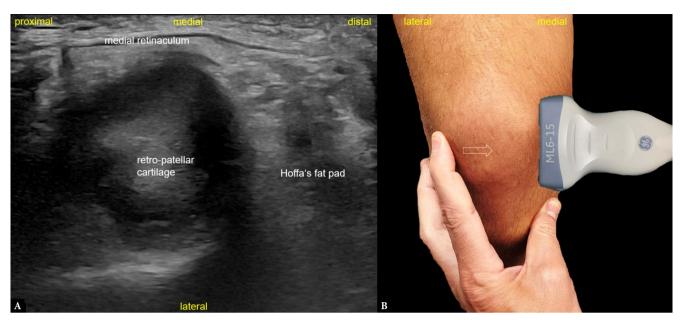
Anterior knee, retropatellar region. A. Longitudinal sonogram of the retro-patellar cartilage. The probe is placed medial to the patella. To obtain this image, the examiner must tilt and move the patella internally, as shown in B (void arrow)
